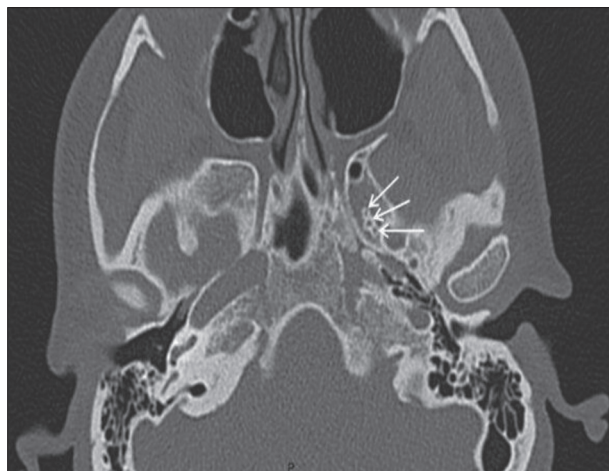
Triple foramen of Vesalius (white arrows) on computed tomography scan
